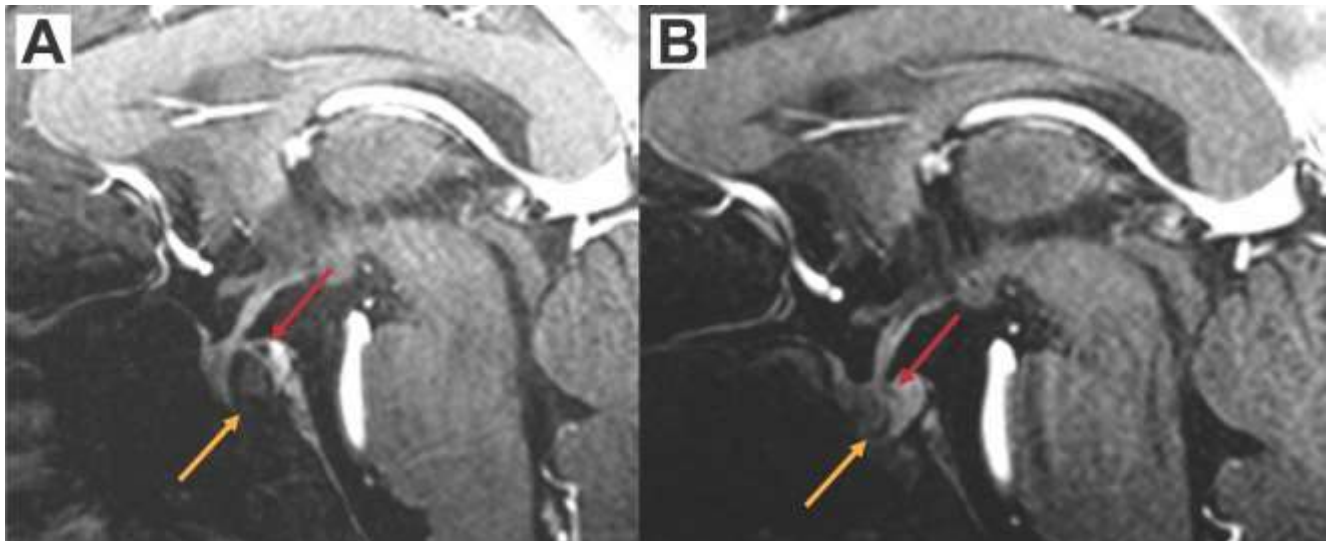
A) A 30-year-old male with pituitary hypofunction. On a sagittal post-contrast 3D-FS-T₁ MPRAGE at 7T, the orange arrow shows a biopsy-proven large Rathke cleft cyst, and the red arrow shows a separate triangular-shaped hypointensity more posterior and superior to the cyst. B) A 3-month follow-up with 7T MRI after endoscopic transsphenoidal drainage of the cyst shows a decompressed Rathke cleft cyst (orange arrow) and a more dilated and prominent appearance of the J-shaped cleft-like presumed Rathke's cleft (red arrow), likely due to resolution of mass effect. Pituitary hypofunction resolved after the surgery.
